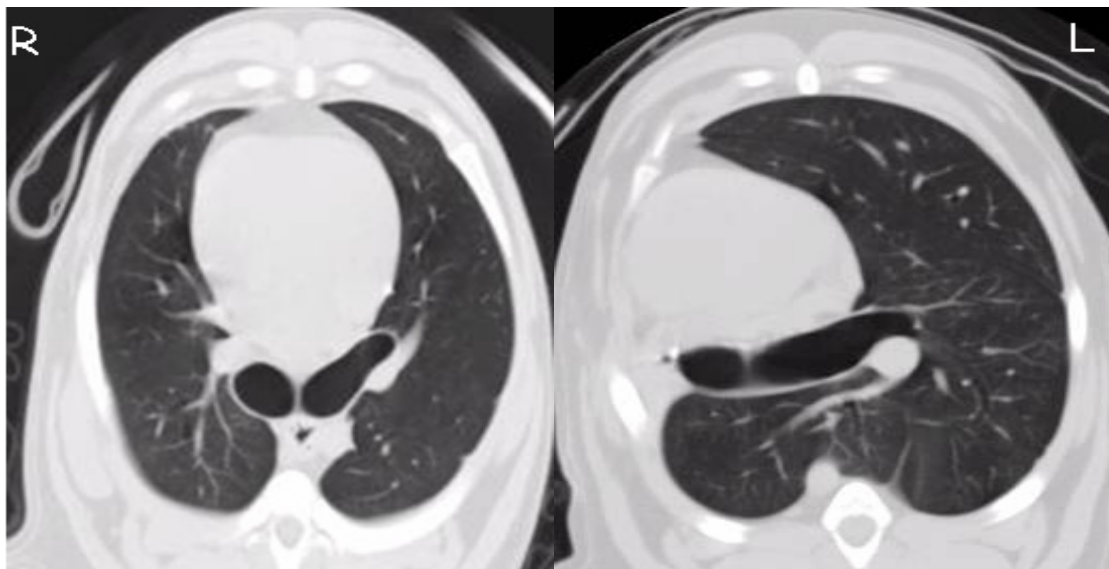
Thoracic CT scan of a foxhound showing mediastinal shift and enlargement of the remaining lung after right pneumonectomy (right) compared with controls (left).
